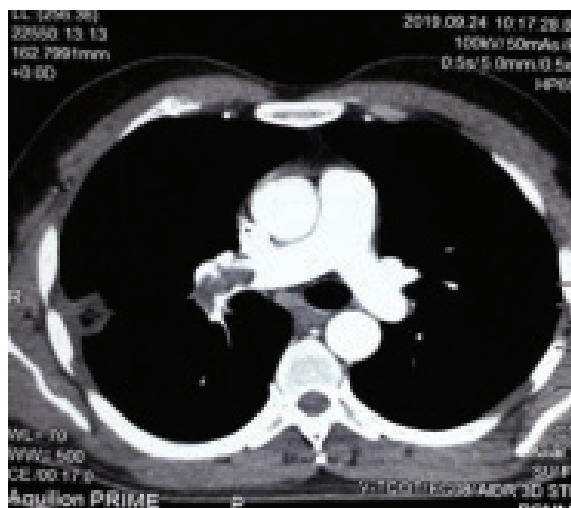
Computed tomography pulmonary angiogram showed thrombus at the bifurcation of right main pulmonary artery
